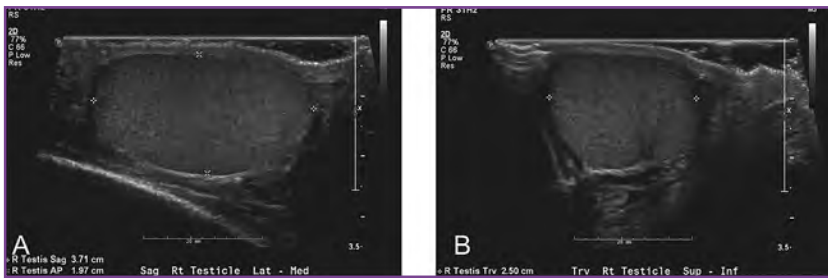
Ultrasonography can be used to obtain the testicular volume by measuring the testis in 3 dimensions: (A) length, width, and (B) depth or height. These diameters can then be used in the Lambert formula to calculate testicular volume in milliliters: length (cm) $\times$ width (cm) $\times$ height (cm) $\times$ coefficient of 0.71.
